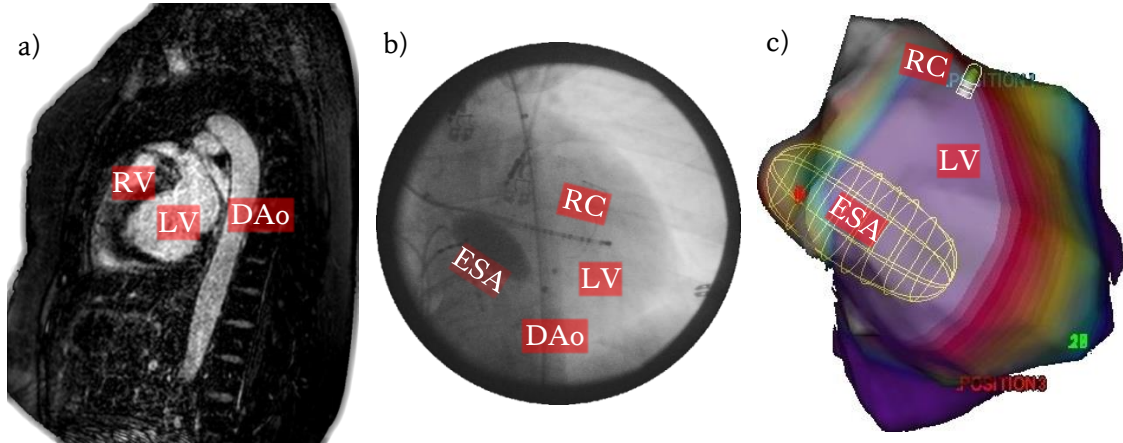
a) A sagittal slice of a patient's torso scan taken from a contrast-enhanced MR image. Left (LV) and right ventricles (RV) and descending aorta (DAo) are labelled. b) Posterior-anterior X-ray view of the heart with intracardiac devices, including the EnSite Array™ (ESA) and roving catheter (RC) in the LV entering via the DAo, and the coronary sinus catheter. c) Example of the EAM information acquired using the EnSite™ System in anterior-posterior views of cardiac action potential depolarisation mapped onto the surface rendering of the LV endocardial wall geometry. The location of the ESA and RC in relation to the LV is also displayed.
